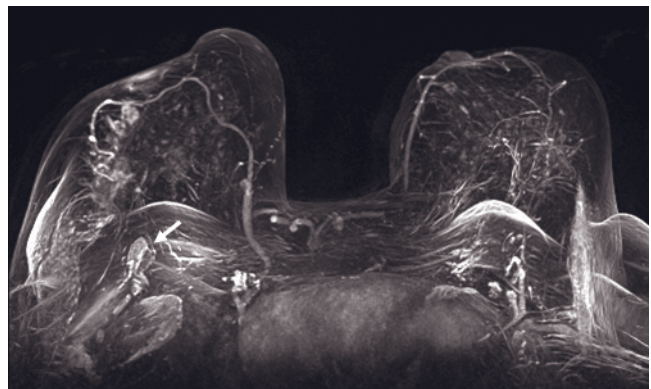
(Continued) curve (e) was the most benign feature of this lesion on breast MRI. Mammographic and sonographic appearances of the lesion were consistent with fat necrosis. Fine needle aspiration (FNA) revealed oily content, confirming the benign nature of the lesion. It was categorized as BI-RADS 3, and 6 months follow-up was recommended.
